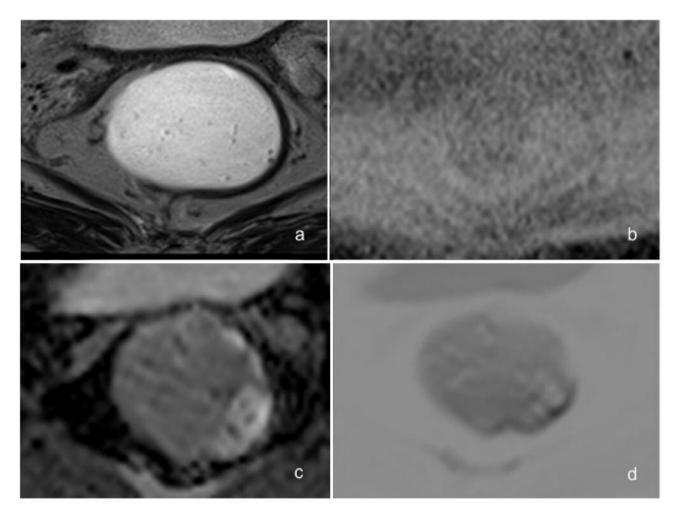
Imaging of a 5-year-old woman with rectal cancer after chemoradiation (Regression Grade 3). a: 2D axial T2-weighted sequence does not show visible tumor. b: b2000 Diffusion-weighted Imaging (DWI) is also negative. c, d: Apparent Diffusion Coefficient map and b800 DWI reveal inferior background suppression (e.g. 'T2-shine-through' of rectal gel) than b2000 DWI.
